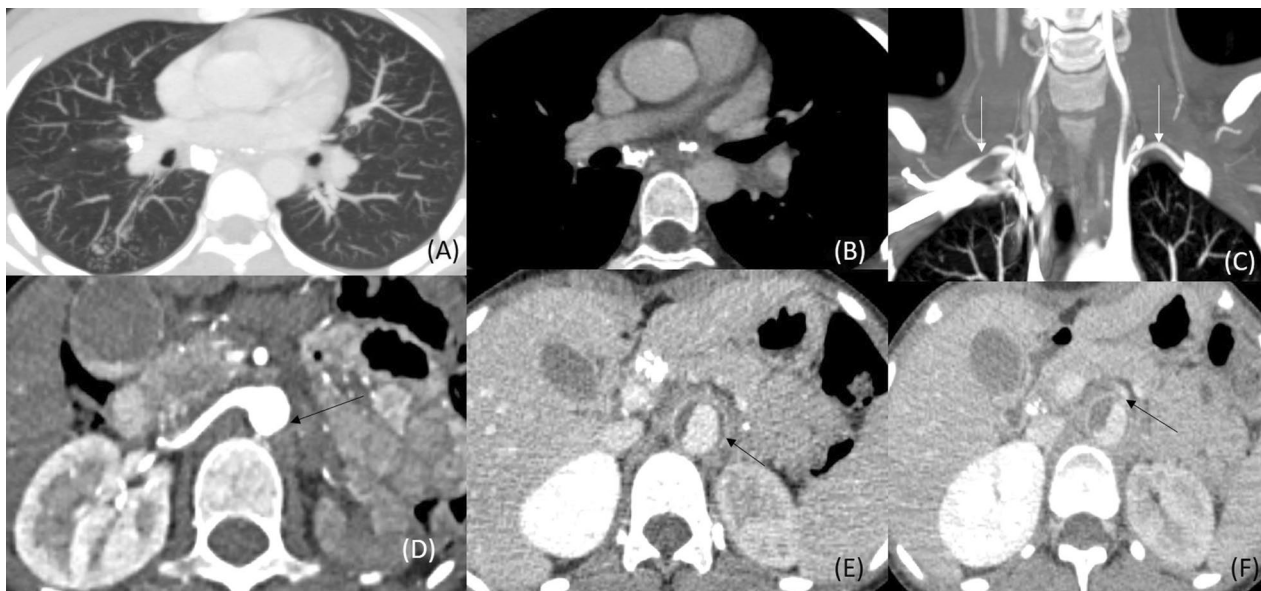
Takayasu arteritis associated with TB. CT images of a 35-year-old female show tree-in-bud nodules (A), calcified mediastinal nodes (B), attenuated calibre of bilateral subclavian arteries (C), complete luminal obliteration of left renal artery (D), wall thickening with luminal thrombus in abdominal aorta (arrow in E), calcified periportal nodes (E) and narrowing at ostia of superior mesenteric artery (F), reduced opacification of left renal parenchyma due to involvement of renal artery (D–F)
